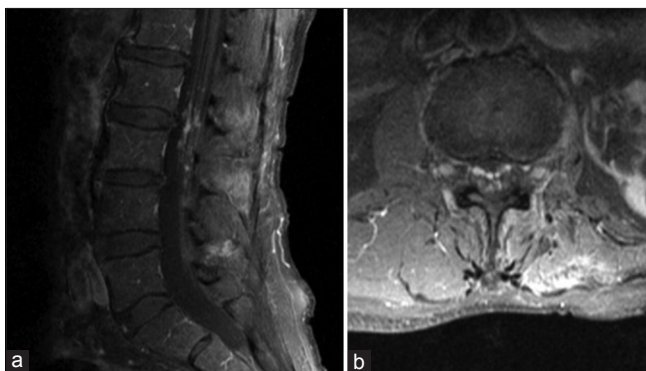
Sagittal (a) and axial (b) T1 with contrast MRI images demonstrating multiple, 2–3 mm, contrast enhancing nodules within the cauda equina
